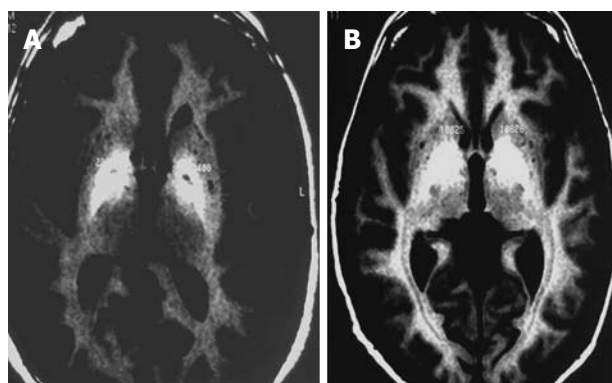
T1 MRI of basal ganglia in cirrhosis: mild (grade 1) signal increase (A) and severe (grade 2) signal increase (B).
